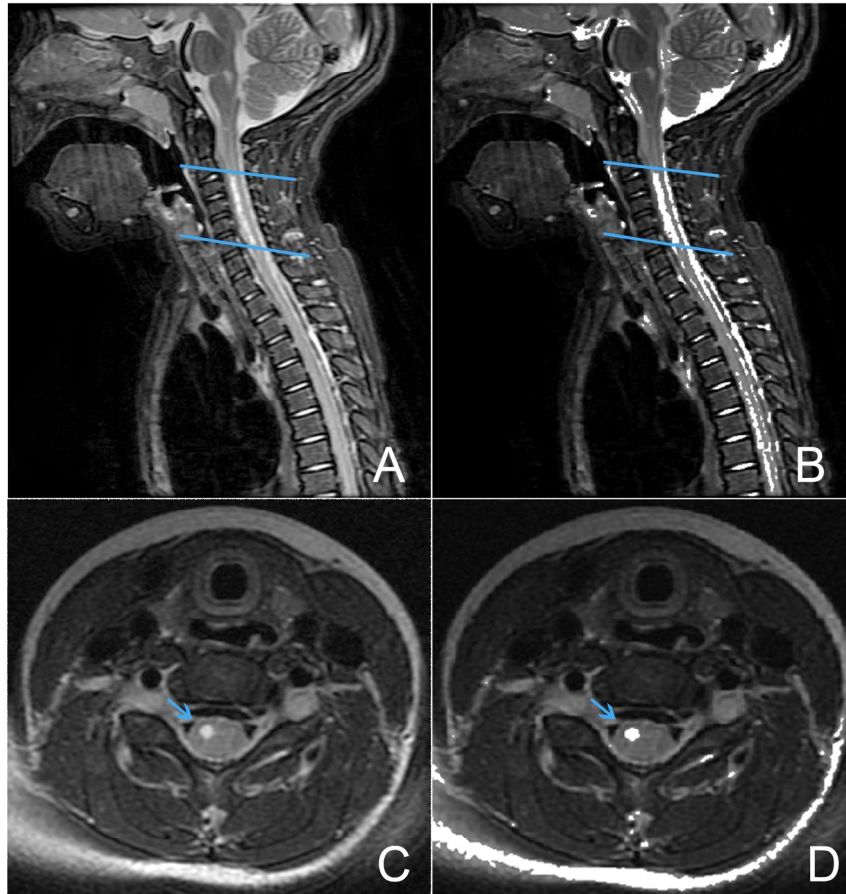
MRI images of patient No. 1. A: Sagittal plane T2 weighted image centered on lesion. B: Overlay of binary thresholded image for lesion and T2 weighted sagittal image. C: Axial T2 weighted image at lesion center. D: Overlay of binary thresholded image for lesion and T2 weighted axial image.
